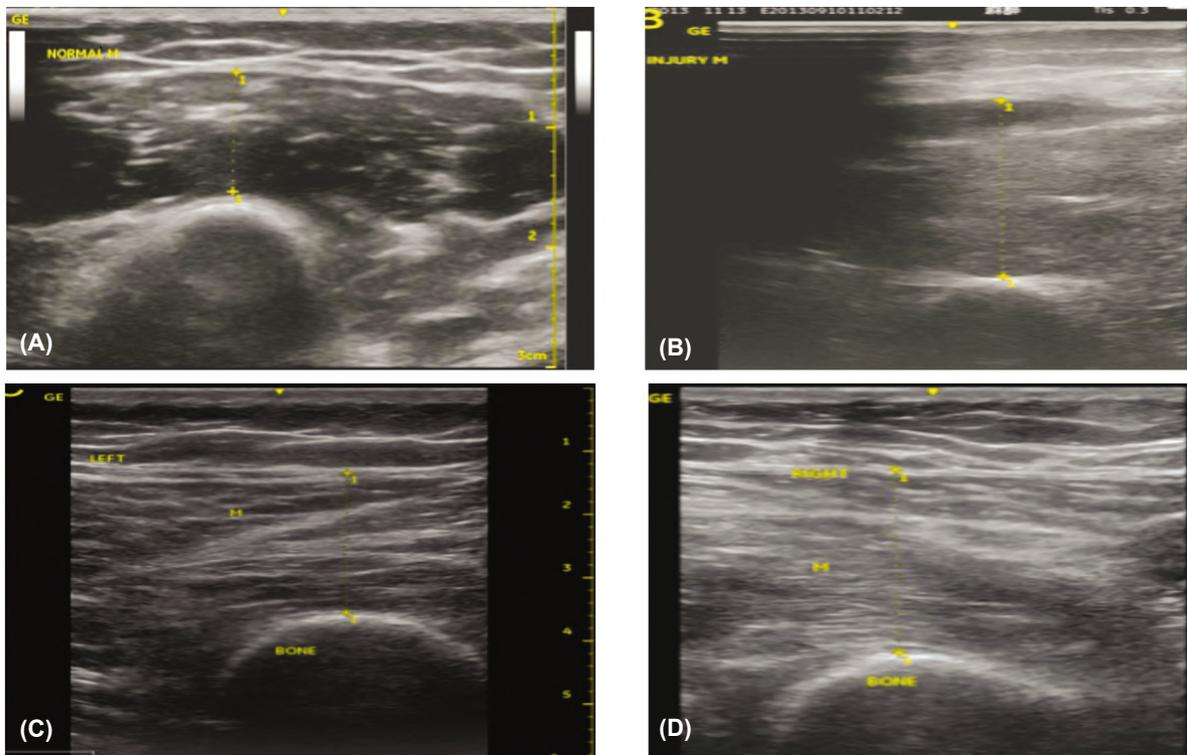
19 years old female patient came to ER after road traffic accident, the ultrasound image shows the diameter growth rate of the muscle is 170%, and this group can be classified as Grade 3; the growth rate exceeds 50% (A&B). The diameter growth rate of the muscle is 12%, and this group can be classified as Grade 2; the growth rate is between 10% and 50% (C&D).
